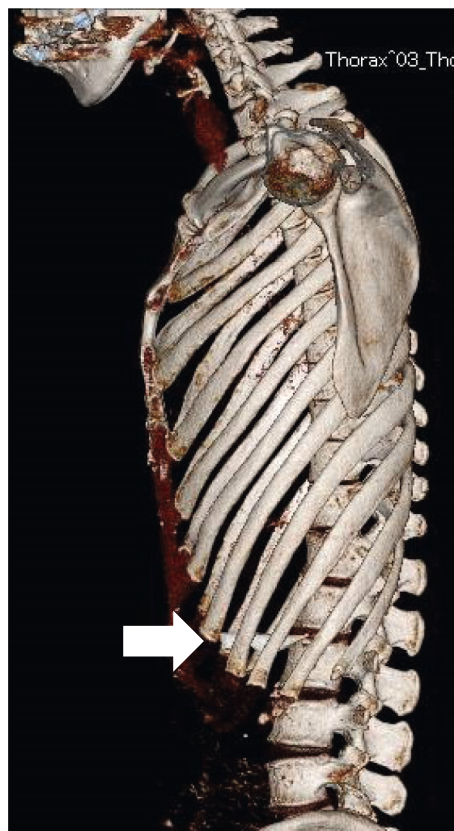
3D-CT image. A knife-shaped foreign body was observed on the left diaphragm angle. The surface was smooth with no irregularities.
